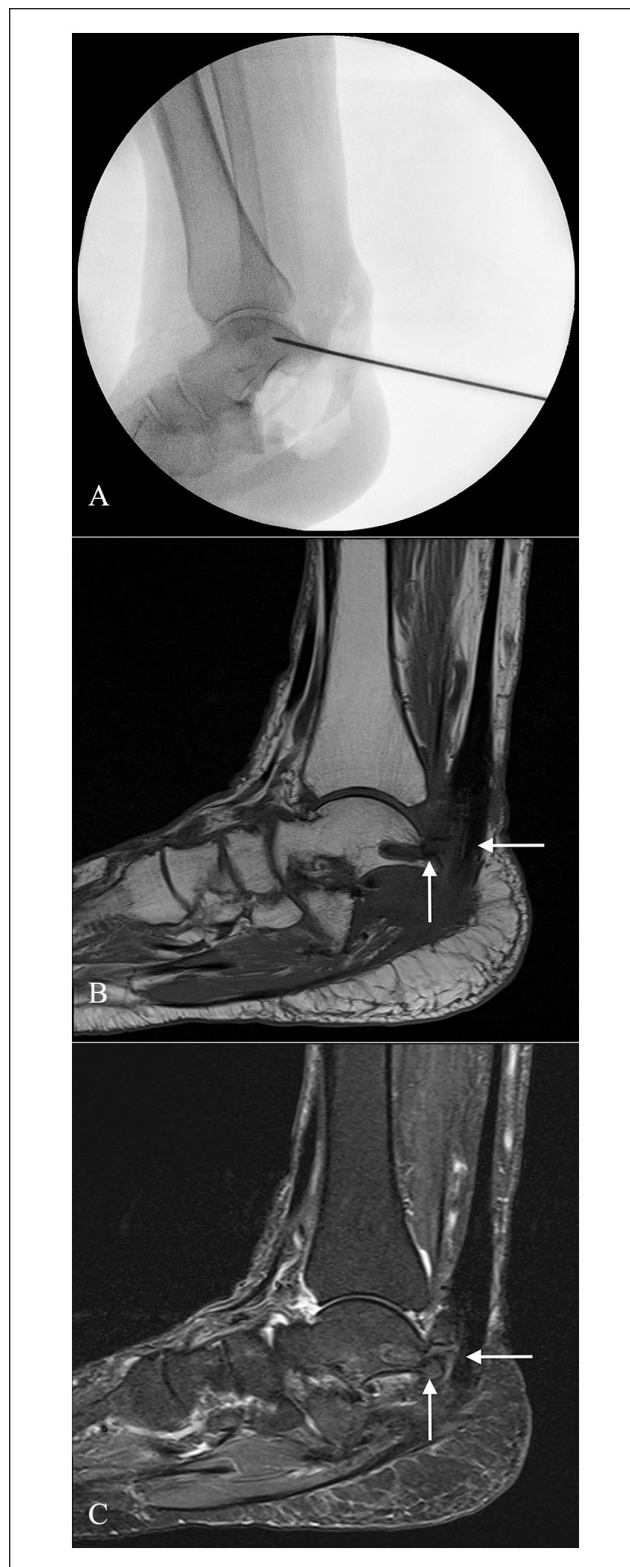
(A) Intraoperative fluoroscopy and preparation for transposition of the Achilles tendon to the posterior talus; postoperative magnetic resonance imaging with (B) T1-weighted turbo spin echo and (C) T1-weighted turbo spin echo fat suppressed without evidence of recurrence, suture anchor with transposed Achilles tendon (arrows).
